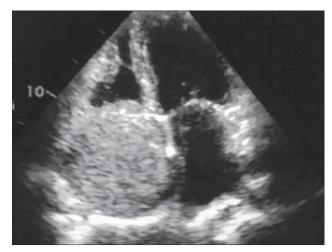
Echocardiography showing large right atrial mass
